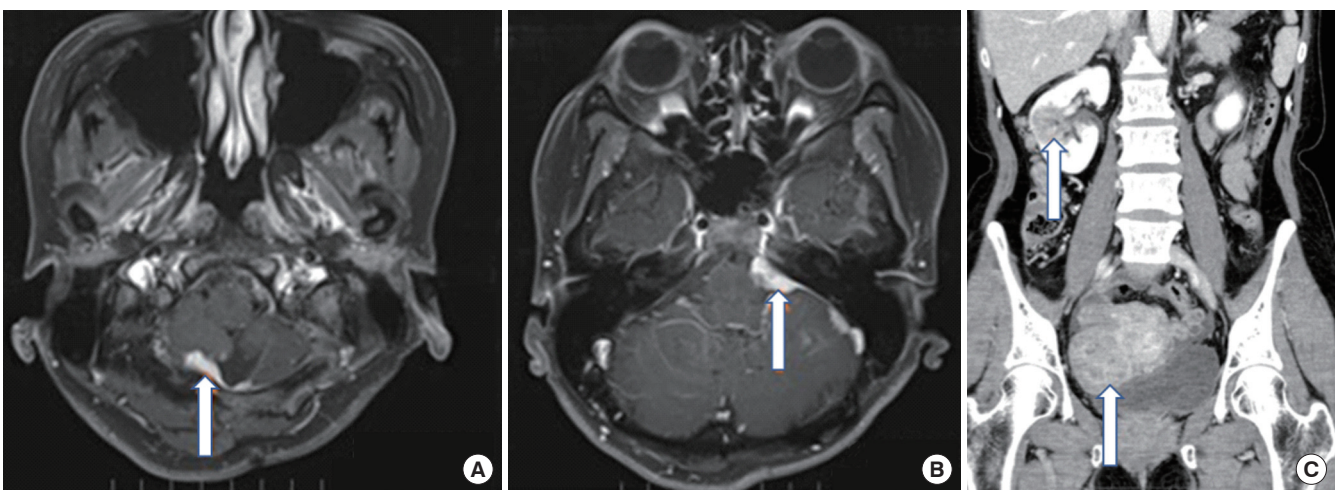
Magnetic resonance images during observation period showing dissemination of the disease with multisystem involvement, dural dissemination (A, B) (arrows), right renal and tubo-ovarian mass (C) (arrow).
